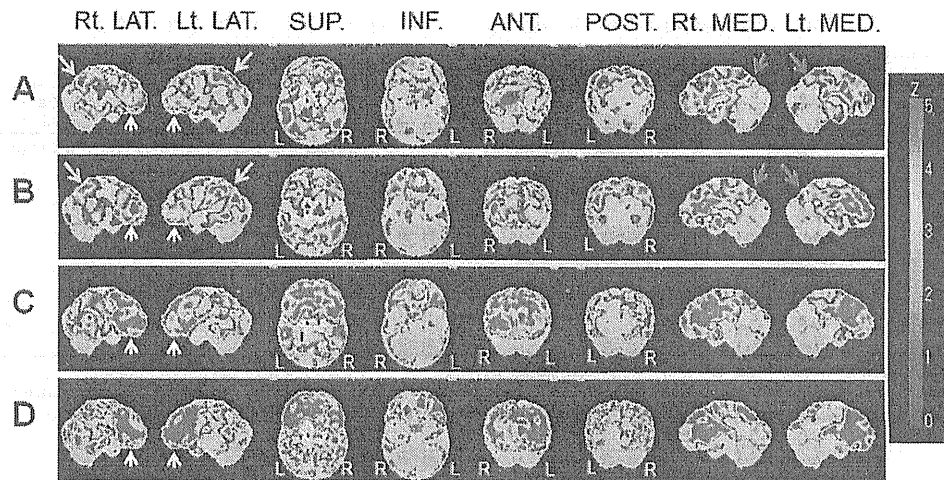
Cerebral blood flow SPECT images. A, B, C, and D show Z-score maps of SPECT images taken when the patient was 34 and 35 years old, after the onset of convulsive seizures when the patient was 36 years old, and one month after the convulsive seizures, respectively. A positive Z score represents a decrease in the regional CBF in the patient relative to the control mean. The red arrows indicate diminished blood flow to the posterior parietal area, including the precuneus. The yellow and white arrows indicate diminished blood flow to the parietal lobe and frontal lobe, respectively. Diminished blood flow to the precuneus, frontal lobe, and parietal lobe was noted even before the onset of convulsive seizures (A, B). After the seizures, however, blood flow to the frontal lobe was markedly diminished (C) and became progressively worse (D). LAT.: lateral, SUP.: superior, INF.: inferior, ANT.: anterior, POST.: posterior, MED.: medial
